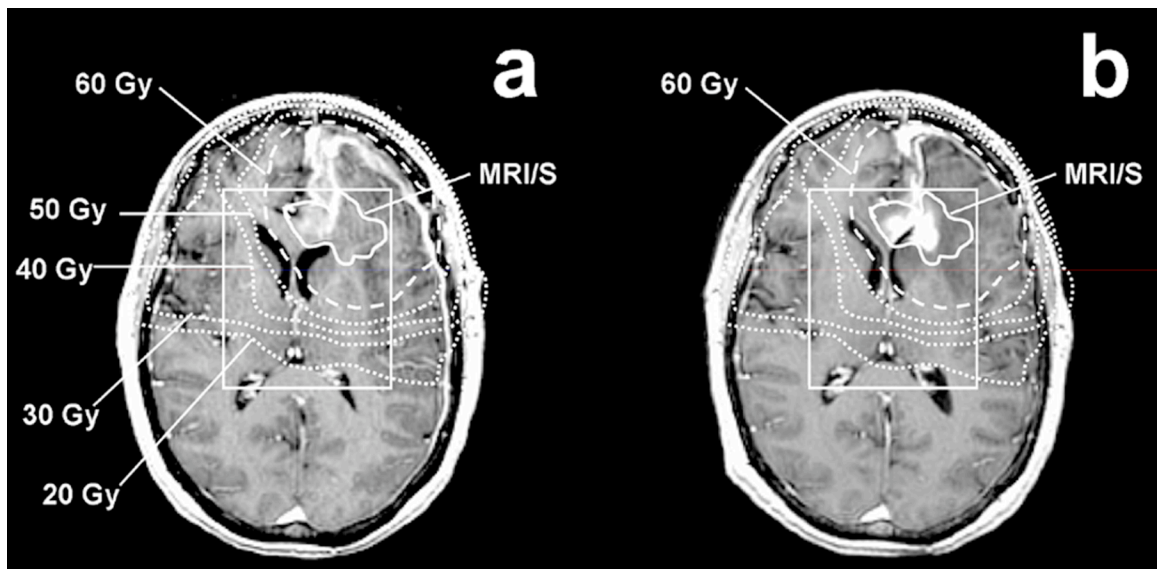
Example of increasing contrast enhancement (CE) within a combined anatomic and metabolic region of interest (MRI/S; solid line) that was covered by 60 Gy (dashed line): (a) T1 spoiled gradient echo (SPGR) pre-radiation therapy (RT), (b) T1 SPGR at 7 months post-RT.
